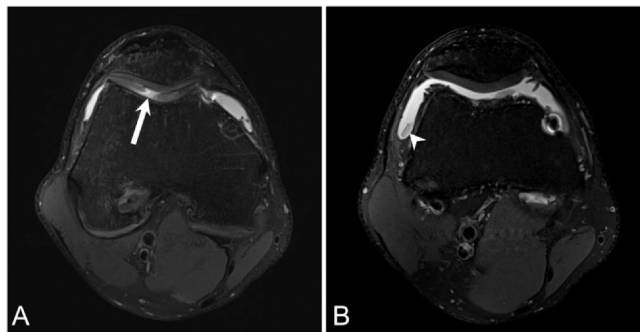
Professional hockey defenseman presents with lateral knee pain. Axial PD FS MR image (A) demonstrates a large full-thickness cartilage defect with adjacent delamination at the lateral aspect of the femoral trochlea (arrow). There is a corresponding intra-articular chondral body in the lateral joint recess (arrowhead) seen a few slices caudal to the level of the chondral defect (B). The susceptibility artifact noted along the medial femoral trochlea is related to the patient's prior ACL reconstruction surgery. ACL, anterior cruciate ligament; FS, fat saturation; MR, magnetic resonance; PD, proton density.
